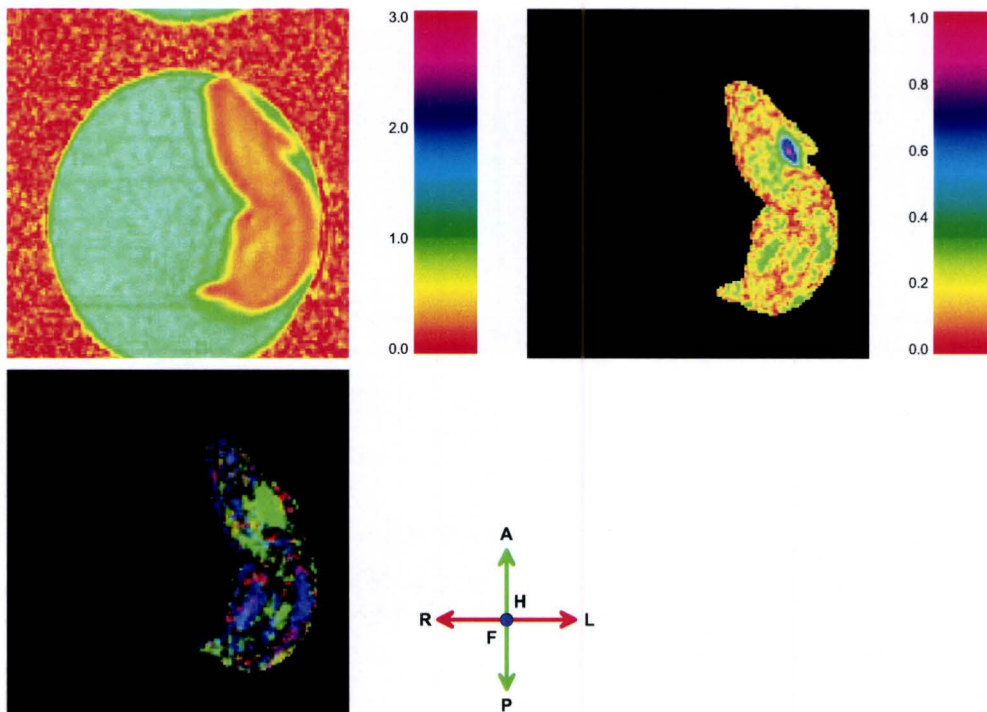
MR images of a non-fixated complete hippocampus, showing Apparent Diffusion Coefficient (top left), Fractional Anisotropy (top right) and Color Code (bottom left) of a transverse slice. The *ADC* is given in units of 10^{-9} m^2/s . Color Code image shows the directional preference of diffusion.
